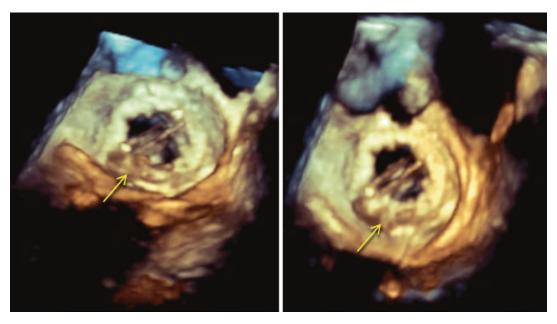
Transesophageal three-dimensional images following replacement of the mitral valve in the patient from the previous figure. The bi-leaflet mitral prosthesis is seen in position and the arrow points to a mass lesion (left
